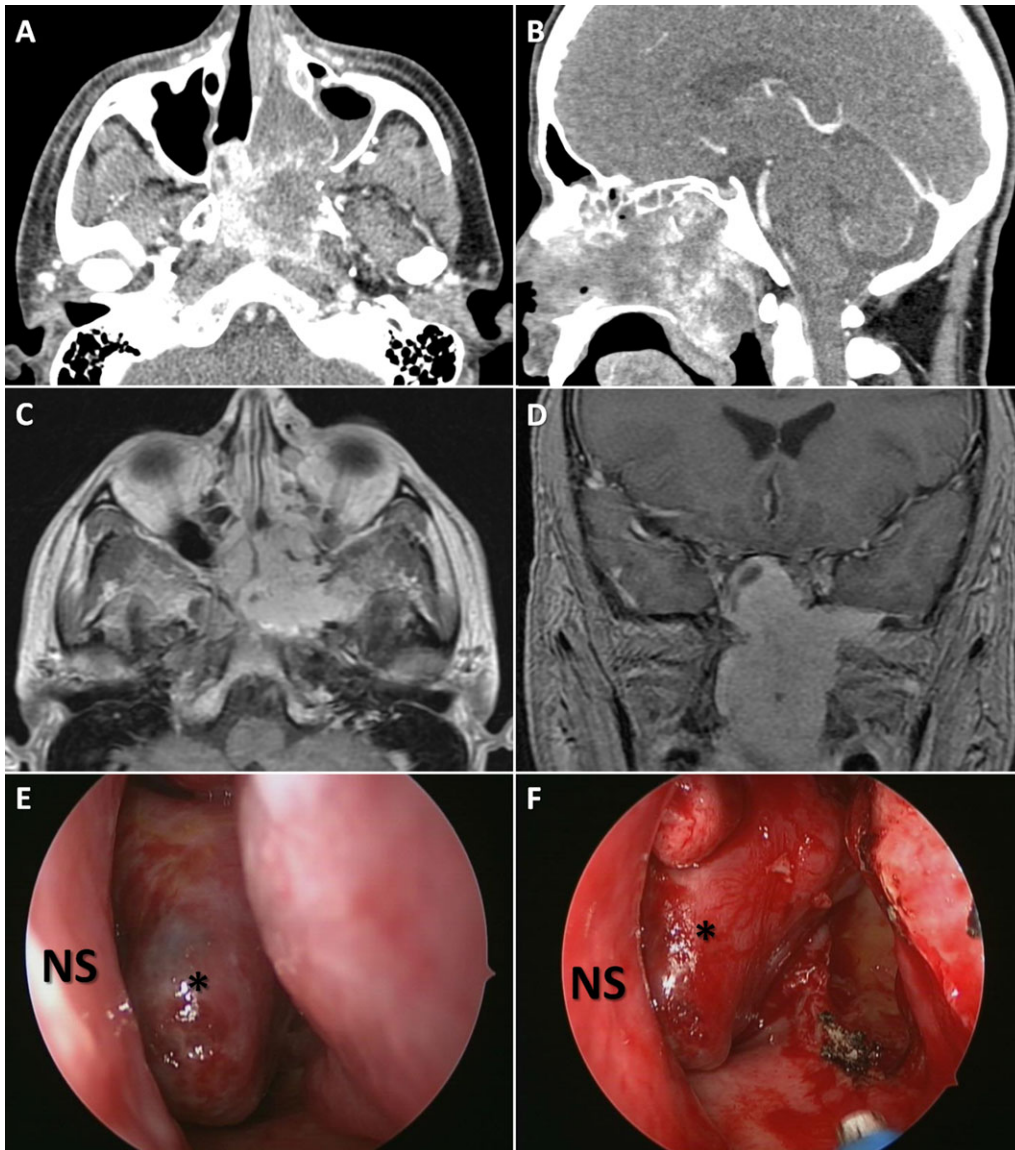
Axial (A) and sagittal (B) contrast-enhanced computed tomography angiogram of a patient with a mostly left sinonasal juvenile nasopharyngeal angiofibroma. Axial (C) and coronal (D) T1-weighted gadolinium enhanced magnetic resonance imaging of the same patient demonstrating the nasopharyngeal angiofibroma. (E) Thirty-degree endoscopic view of the left sinonasal mass. (F) Endoscopic view of the lesion after endoscopic modified left medial maxillectomy. Asterisks depict lesion. NS = nasal septum.
